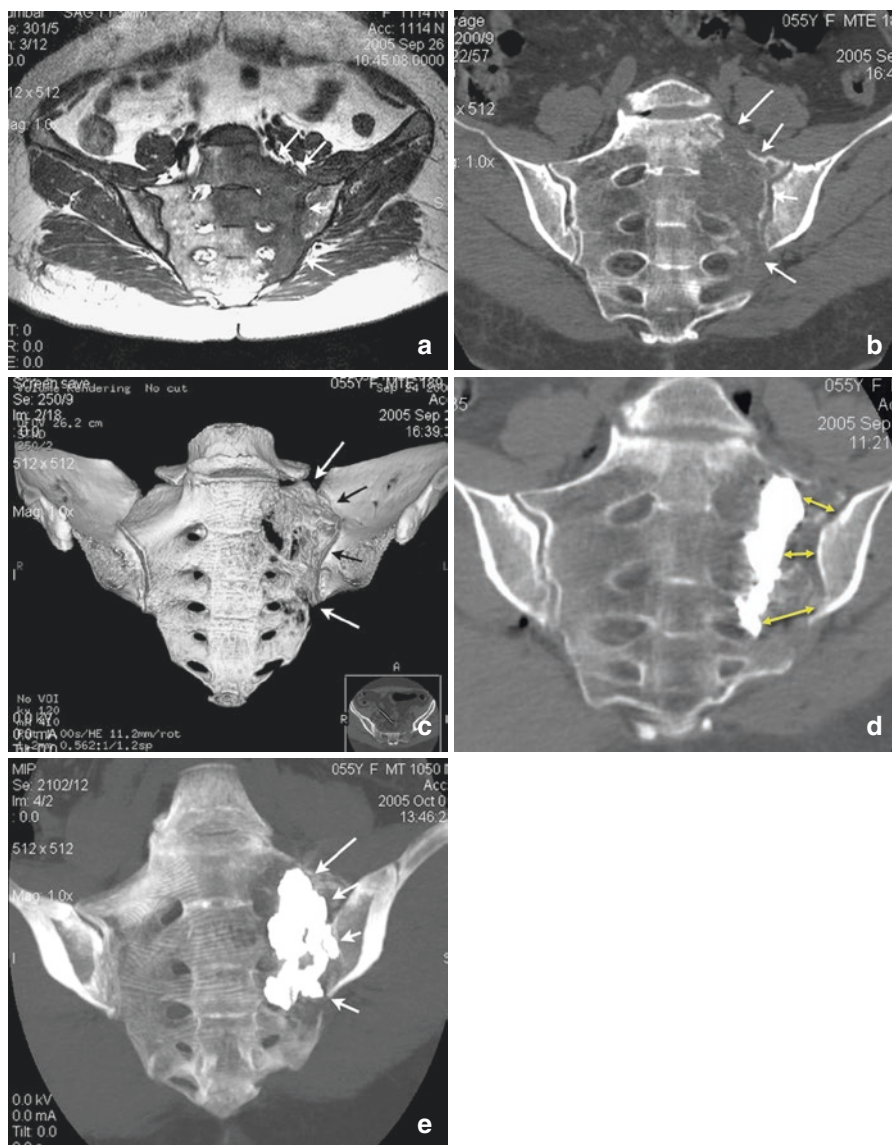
Left wing and S1–S2 sacral body lymphoma. On coronal MR T1SEw scan (a), abnormal signal intensity of the left hemisacrum is appreciated. 2D (b) and 3D (c) coronal CT image demonstrates large osteolysis of the left sacrum. First PMMA injection was considered insufficient from a biomechanical point of view, according to residual lytic gap between the intrasacral PMMA and the iliac bone (arrows in d). A second PMMA injection was performed, to completely restore the sacroiliac joint (e)
